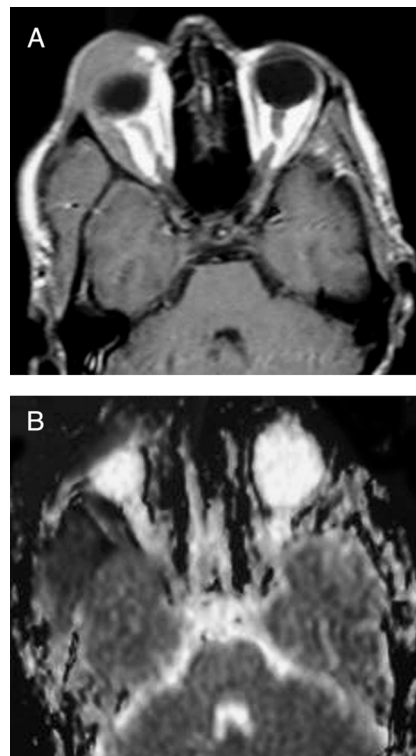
Non-Hodgkin lymphoma of the temporal fossa. (A) Axial contrast T1-weighted image showing a large infiltrating and enhancing mass in the right temporal fossa, with extension into the right lateral rectus muscle and pre-septal space in front of the right globe, and right proptosis. (B) ADC map showing restricted diffusion, with a low ADC value ( $0.83 \times 10^{-3} \text{ mm}^2/\text{s}$ ) of the lesion in the right temporal fossa, right lateral rectus muscle, and pre-septal space.
